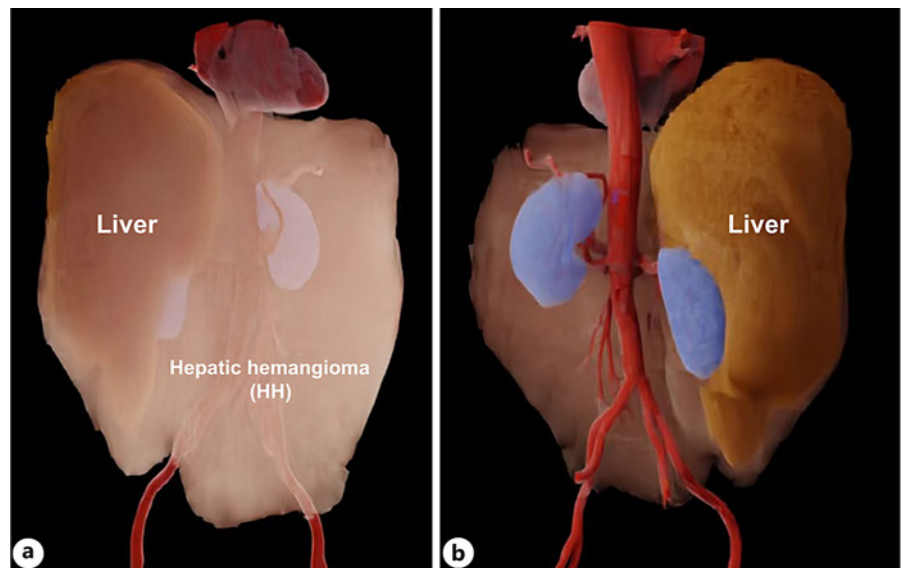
a, b CT HRR showed the relationship of the mass and its surrounding organs. HRR, hyper-realistic rendering.
